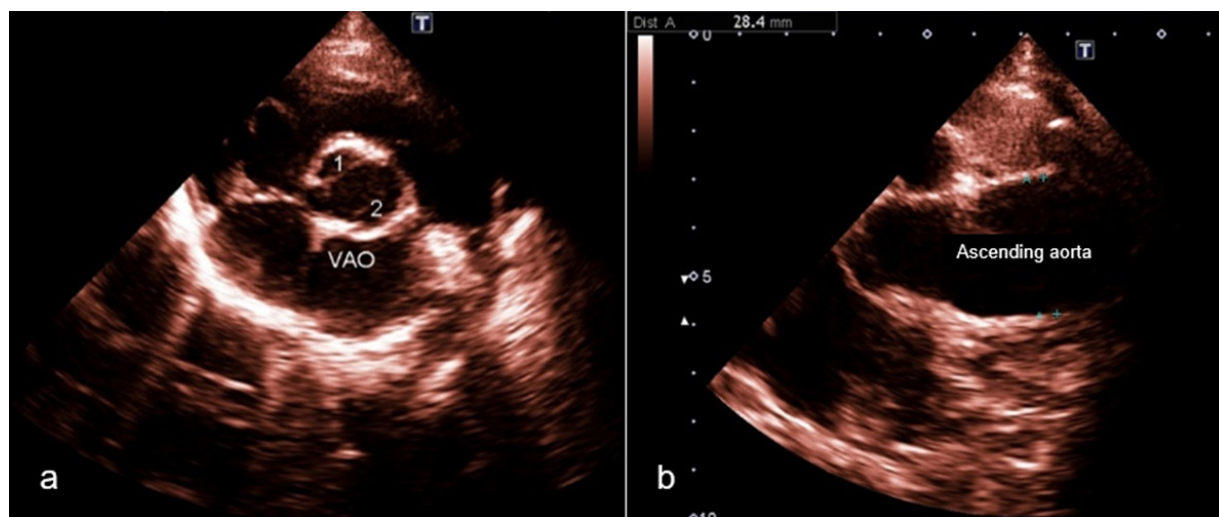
Two-dimensional mode echocardiogram: (a) Bicuspid aortic valve; (b) Significant enlargement of the ascending aorta. VAO: aortic valve.
